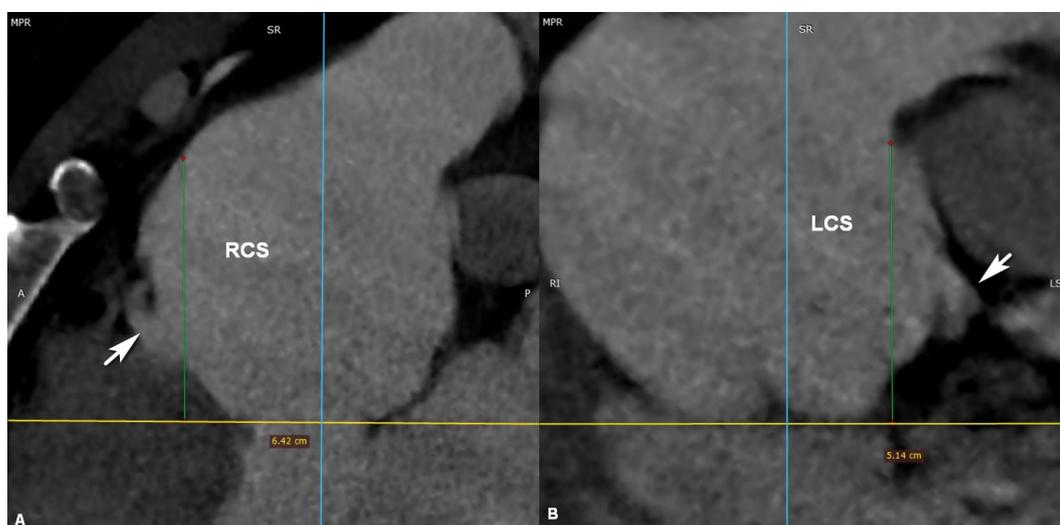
Computed tomography images of the measurement of the sinus of Valsalva height in male with Marfan syndrome and aortic root aneurysm. (A) The height of the right coronary sinus (RCS) and (B) the left coronary sinus with the appropriate coronary arteries (white arrow).
